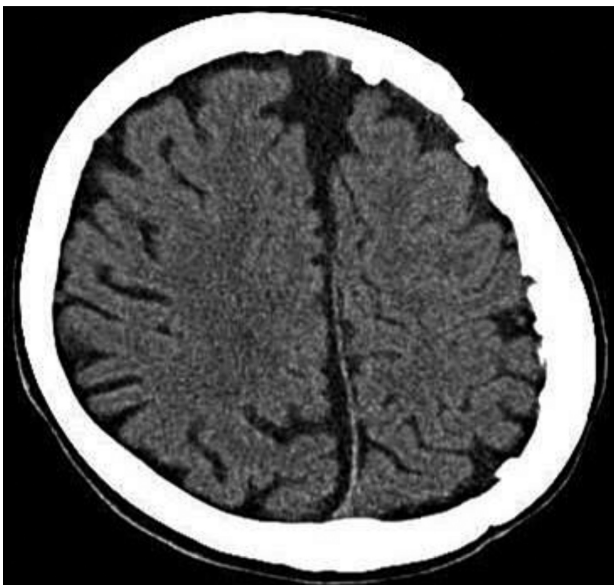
About 3 years after surgery, follow-up computed tomography demonstrated an improvement of mass effect and good re-expansion of the brain. In addition, sulcus effacement signs in the left hemisphere had disappeared, and no recurrence of haematoma was noted.
